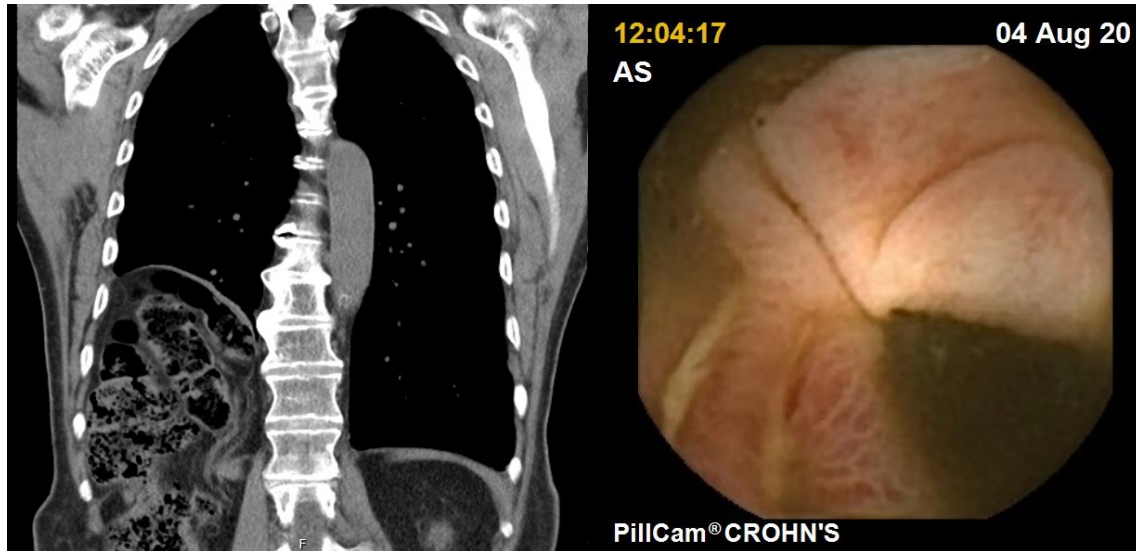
Left image - Previous chest CT of the patient, revealing the Bochdalek hernia on the right hemithorax; Right image - Frame of the capsule endoscopy performed, showing a congested mucosal surface, with small linear ulcers.
